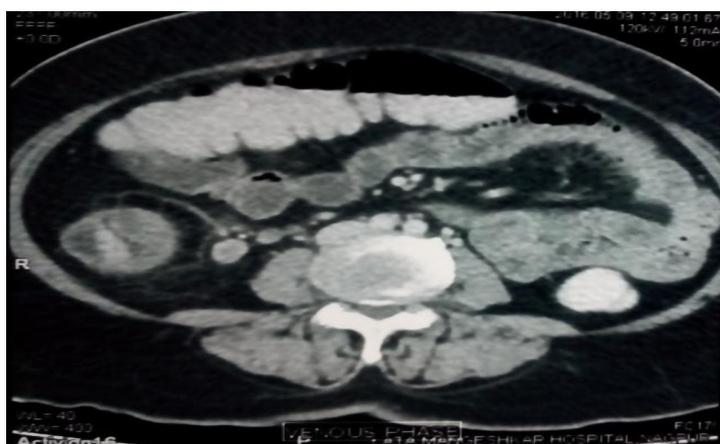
Abdominal computed tomography showing circumferential wall thickening of the ascending colon resulting in luminal narrowing with significant fat stranding and multiple pericolic lymphadenopathy.
